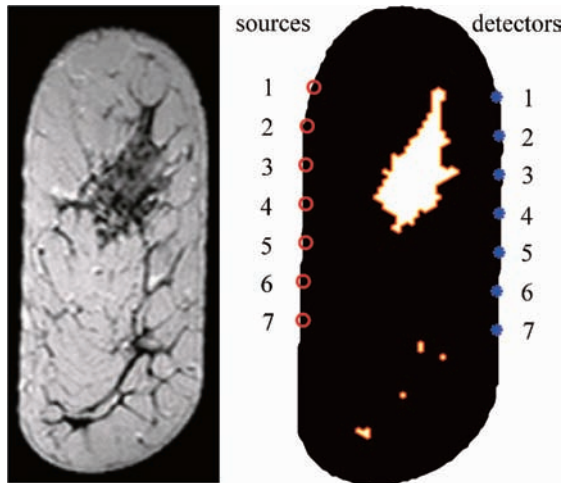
(a) The inplane coronal slice of the T1-weighted MR image is shown for the right breast of the subject imaged. This image was used to create a mesh with segmentation of the adipose tissue (black) and the fibroglandular tissue (white) in (b). The positions of source and detector fibers are marked accordingly with circles.
